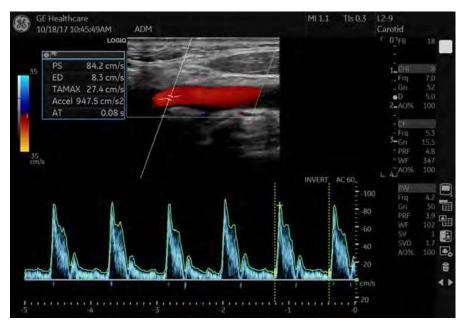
PW Doppler Mode Display
